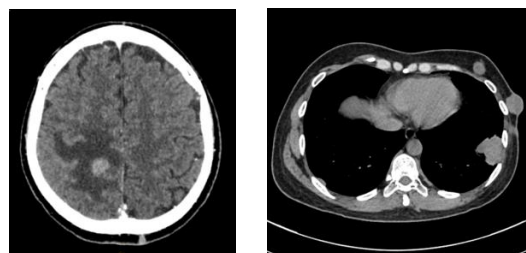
MRI images showing new metastases
